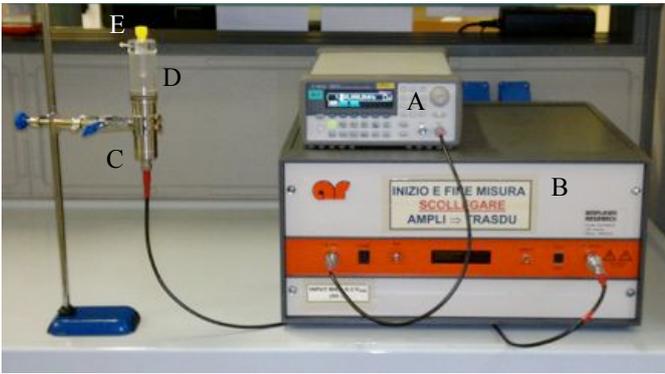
Ultrasound generation System: A) Function generator; B) Amplifier; C) Piston like ultrasound transducer; D) Mechanical adaptor; E) Burette
